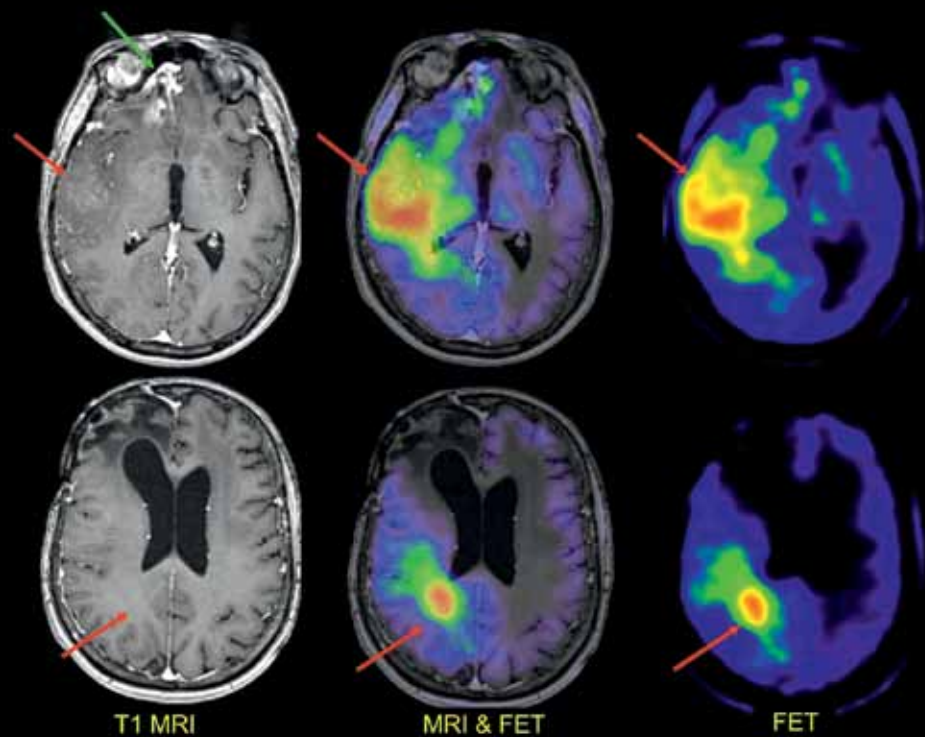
Patient with malignant high grade tumor treated with surgery, radiation-chemo-therapy and antiangiogenic treatment (Bevacizumab). There is a large recurrent metabolically active tumor (red arrow) that is only partly manifest on MRI. Other changes on MRI are not recurrent tumor (green arrow).
